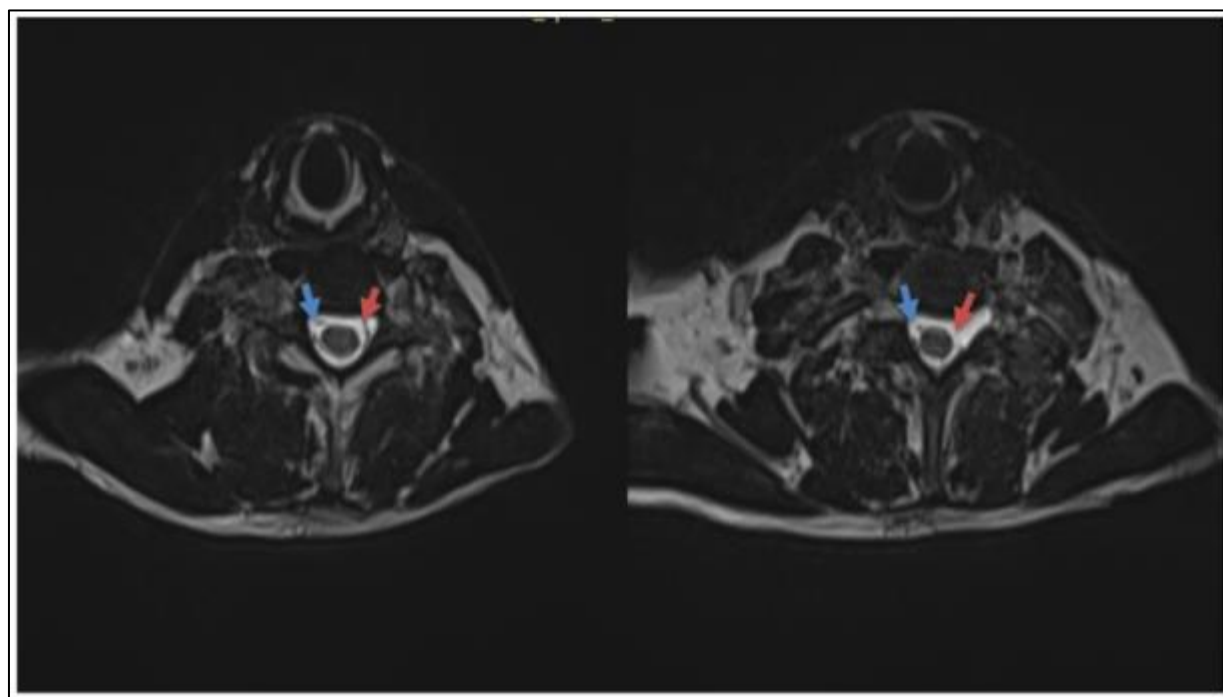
(A) Axial T2-weighted image at the C6–C7 level demonstrating non-visualization of the left C7 nerve root (orange arrow), with normal contralateral right C7 root visible as a hypointense dot within the hyperintense cerebrospinal fluid (blue arrow). (B) At the C7–T1 level: absence of the left C8 nerve root (orange arrow) with preserved right C8 root (blue arrow). These findings constitute the root absence sign, the most specific indicator of preganglionic avulsion.
